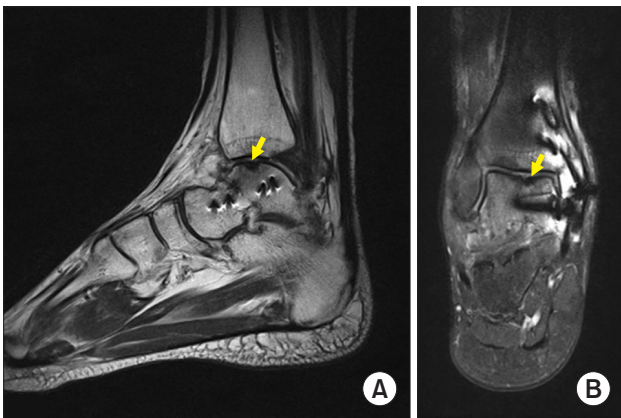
A 31-year-old man who sustained a Hawkins's type III talar neck fracture in a traffic accident. (A, B) Magnetic resonance imaging taken 2 months after surgery shows evidence of avascular necrosis in the talar dome (yellow arrows).
